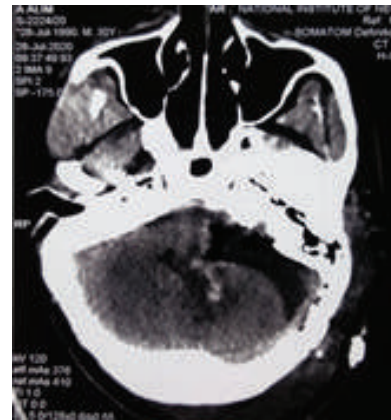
Postoperative CT scan of VS
